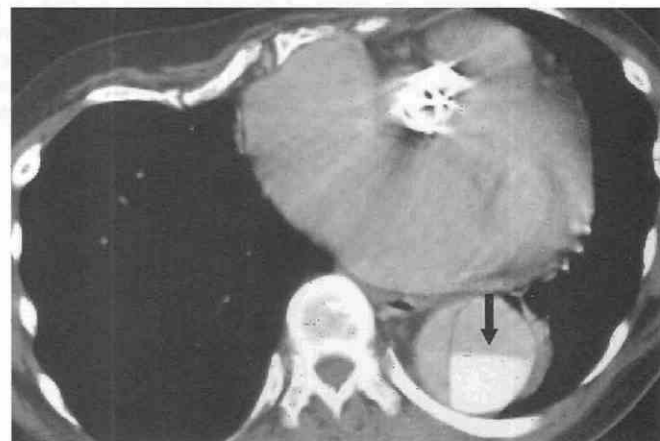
Axial CT scan of the descending aorta shows markedly delayed clearance of contrast medium in the false lumen (arrow) in a patient with Marfan's syndrome and type B dissection.
